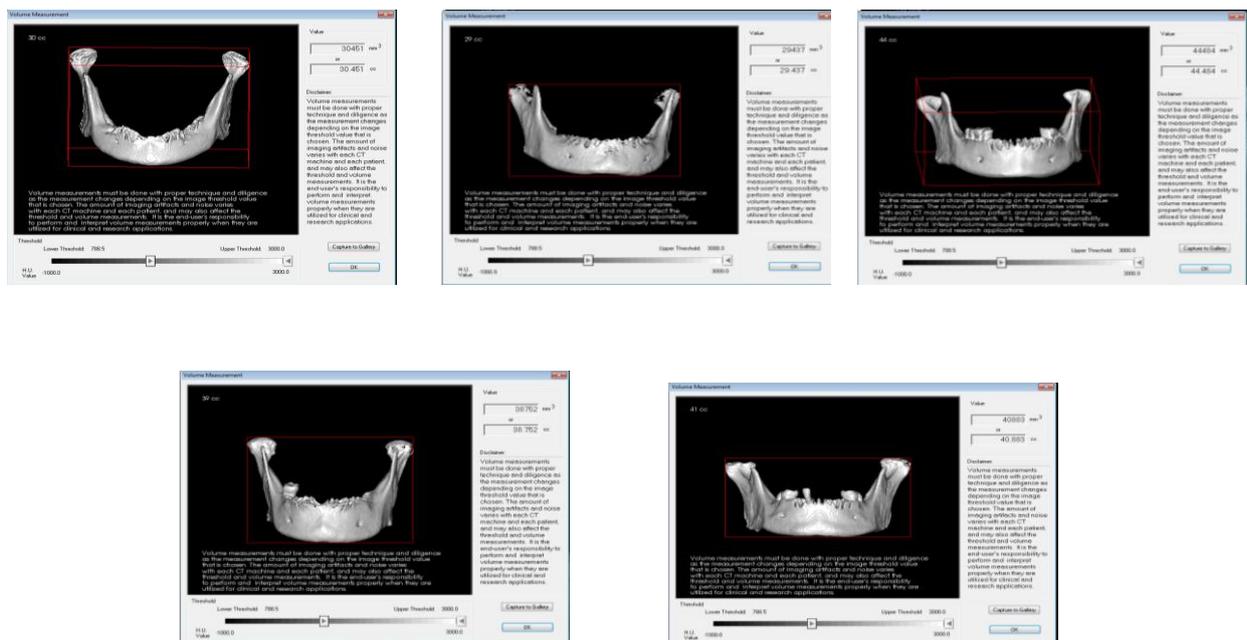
Volumetric measurement of mandible using CBCT
